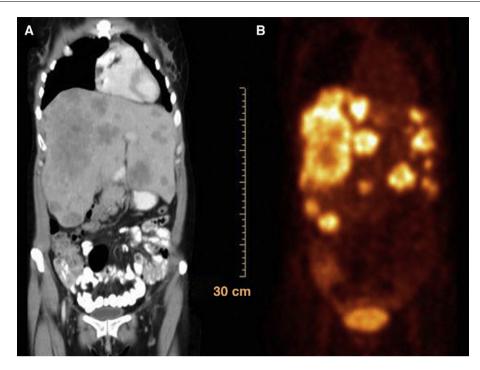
(A) CT image showing the hepatic parenchyma replaced by lesions indicative of metastasis. (B) PET scan confirming multiple metabolic hyperactivity centres in the liver.
